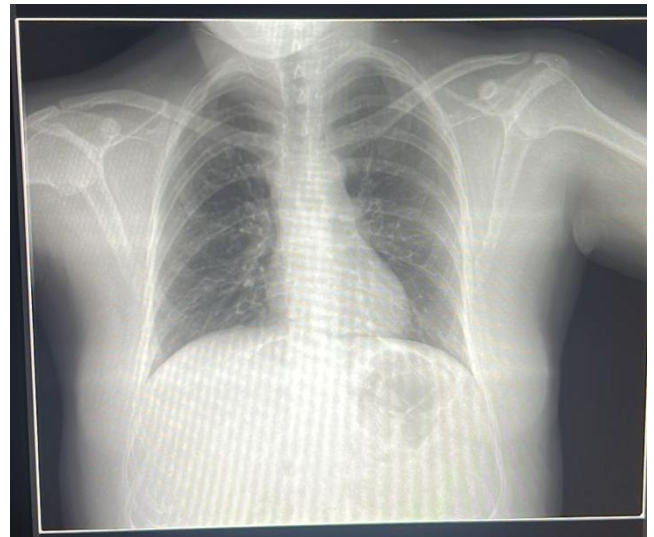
Anteroposterior (AP) chest X-ray upon admission. No acute cardiopulmonary findings are evident.
